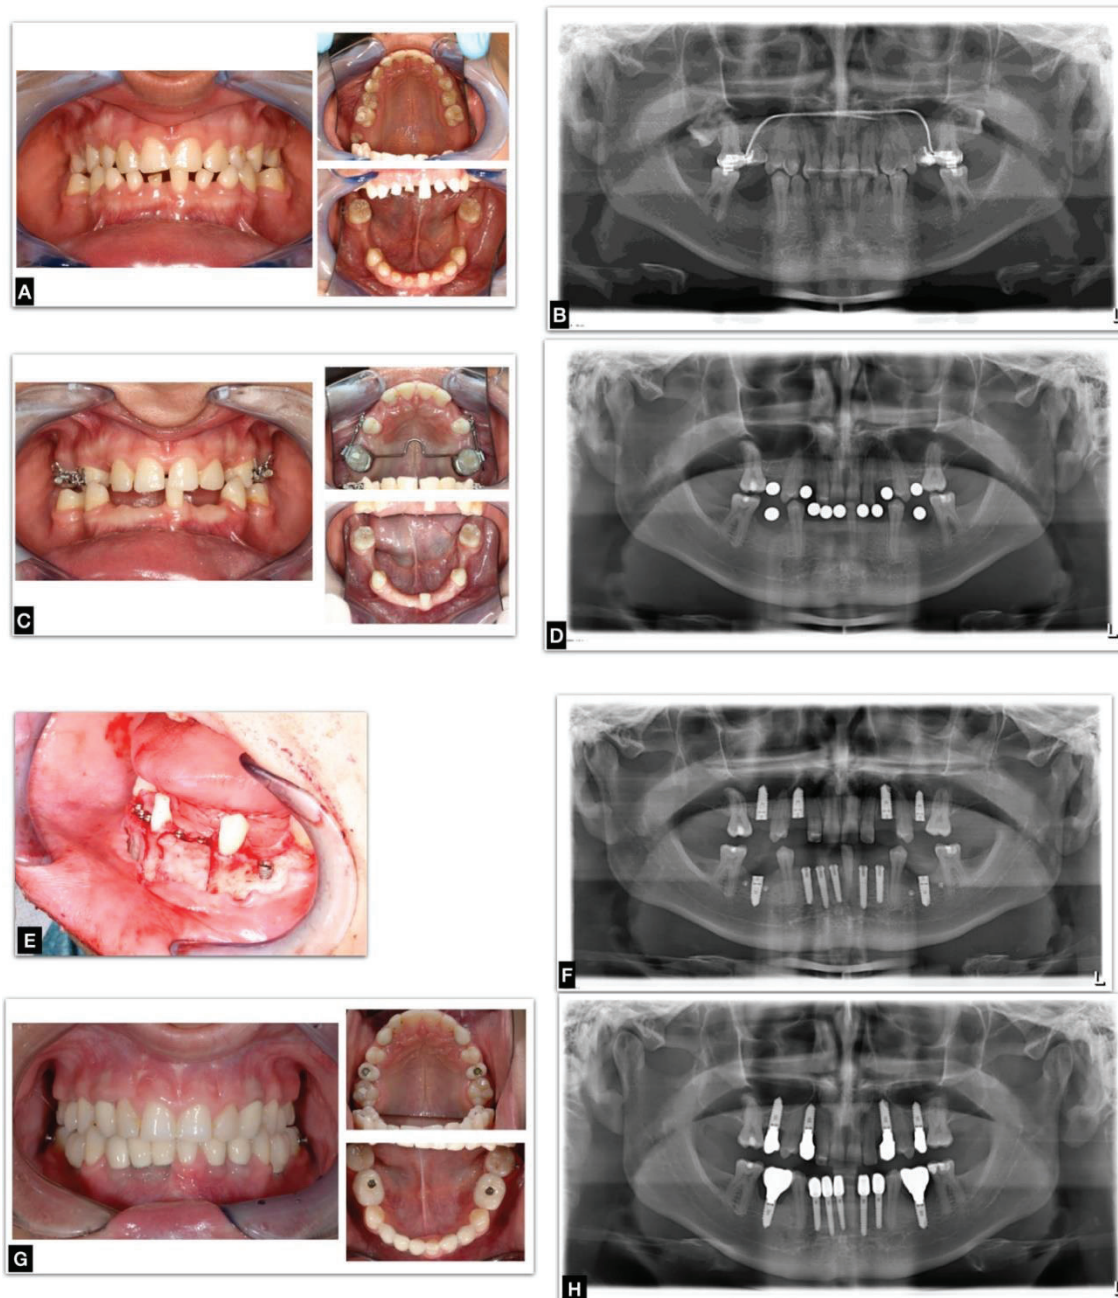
Patient with oligodontia: A) initial situation with some deciduous teeth still in situ (55, 53, 63, 65, 73, 72, 81, 82, 83); B) panoramic x-ray related to the initial situation; C) condition after extraction of the deciduous teeth. There was a crossbite in the posterior region due to the size discrepancy between the upper and lower jaws. To create space for the subsequent implants, orthodontic gap opening was performed. D) Panoramic x-ray for implant planning with references; E) intra-operative photo showing the implant insertion with the bone-splitting technique; F) panoramic x-ray after implant placement; G) the situation after prosthetic rehabilitation; H) panoramic x-ray after crown insertion. Clinical case of the Department of Oral and Maxillofacial Surgery, University Hospital Giessen.
